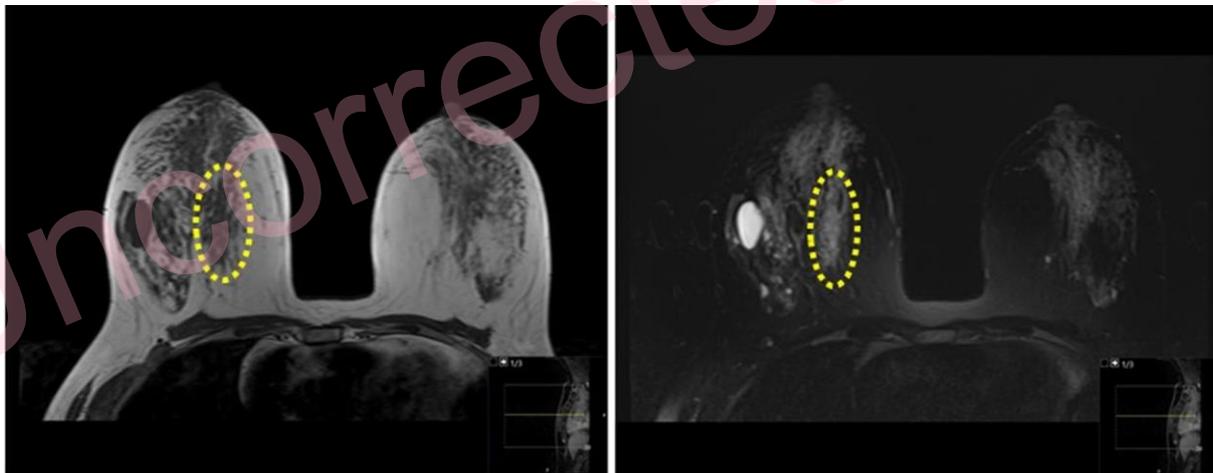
On the T1W and T2W MR images; circle indicates asymmetric tissue in the upper inner quadrant of right breast with equal signal to the breast tissue on T1W MR image and slightly hyperintense on T2W MR image.
